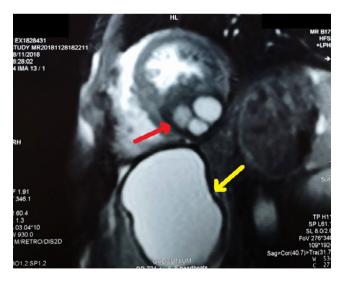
Axial MRI showing both <u>cardiac (red arrow) and hepatic (yellow arrow)</u> cysts
